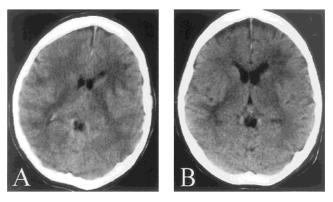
Case 2. Computed tomographic scans of a 65-year-old woman with pneumococcal meningitis. (A) A CT scan on day of admission showed extensive brain edema with sulcal effacement. The diffuse white matter hypointensity suggests white matter edema or beginning cerebritis. (B) On day 7, cerebral edema was markedly improved, and no signs of severely raised ICP could be detected. A subsequent ventriculostomy revealed ICP values up to 45 mmHg.
